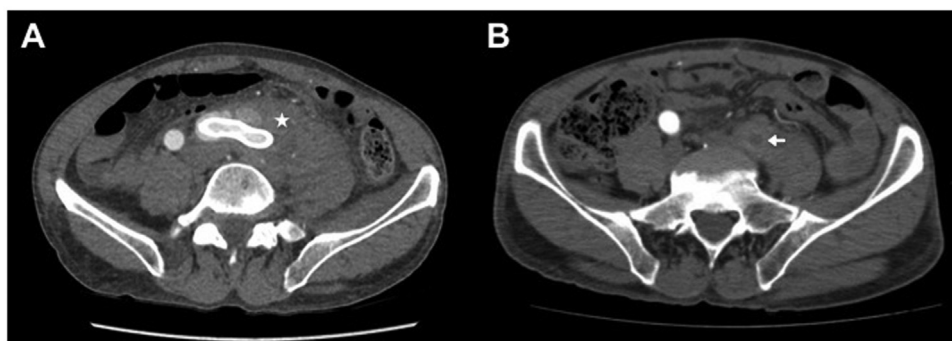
CT angiography axial slices of the patient with the *Pseudomonas stutzeri* prosthetic left iliac artery graft infection. A. Image before removal of the graft, demonstrating retroperitoneal soft tissue inflammatory changes around the left common iliac prosthetic graft, with extension into the left psoas muscle (star). B. Image after removal of the graft, demonstrating marked reduction of the retroperitoneal inflammatory changes. There is interval thrombosis of the left common iliac artery (arrow).
